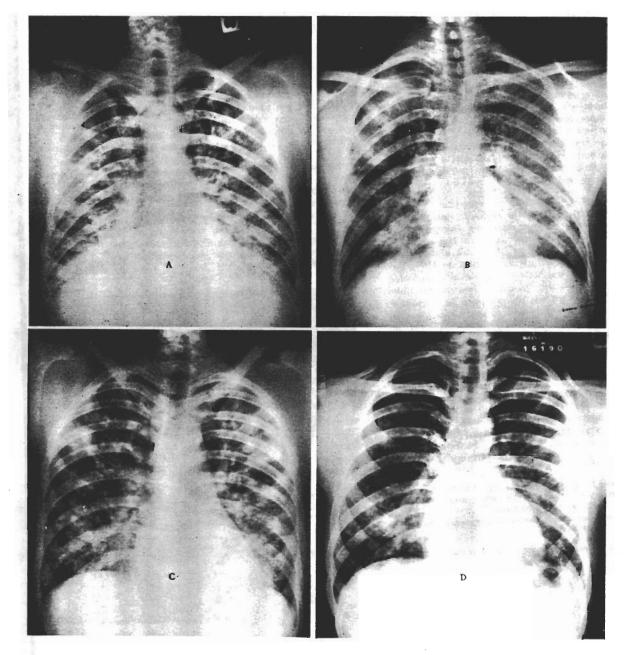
X-ray Films of the Chest of Cases 1 (A), 2 (B), 3 (C) and 4 (D) (for Details. See Text).
